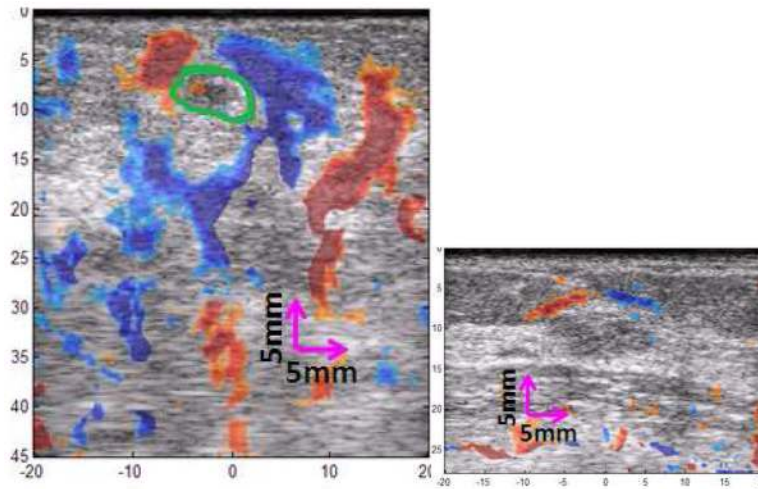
Additional example images of ASSE as a color-overlay on the sonogram of a (left) cancer and (right) fibroadenoma are shown. The observer's outline (green line) of the tumor appearance on the sonogram of cancer is also shown.
